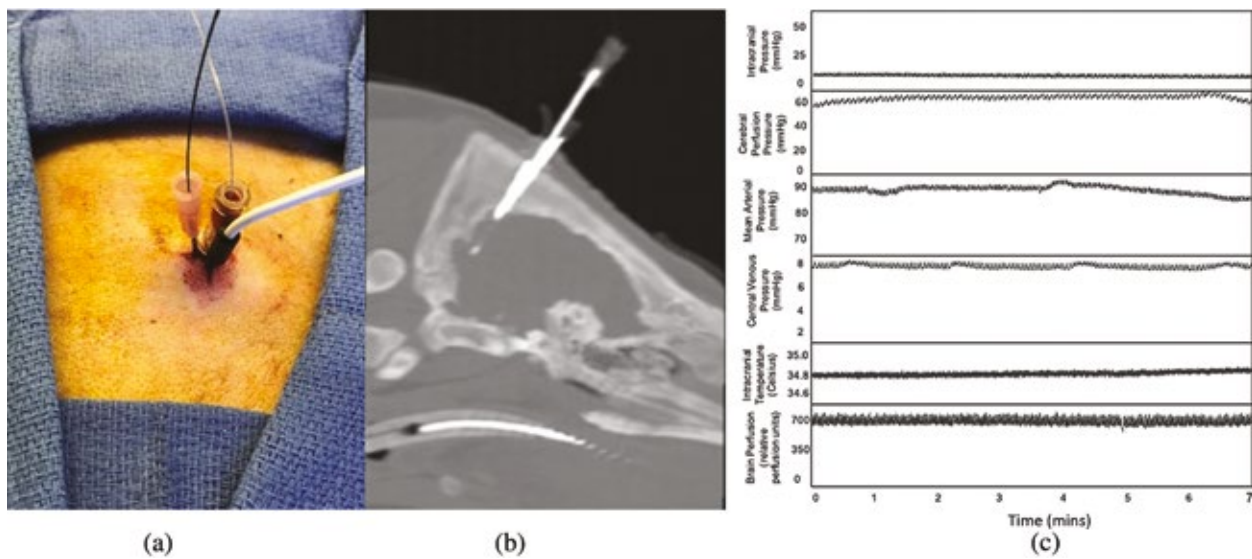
Neuromonitoring suite in place and representative data captured. (a) Image of burr hole with neuromonitoring probes in place. (b) Example of CT confirming placement of neuromonitoring suite. (c) Graph of representative neuromonitoring data.
